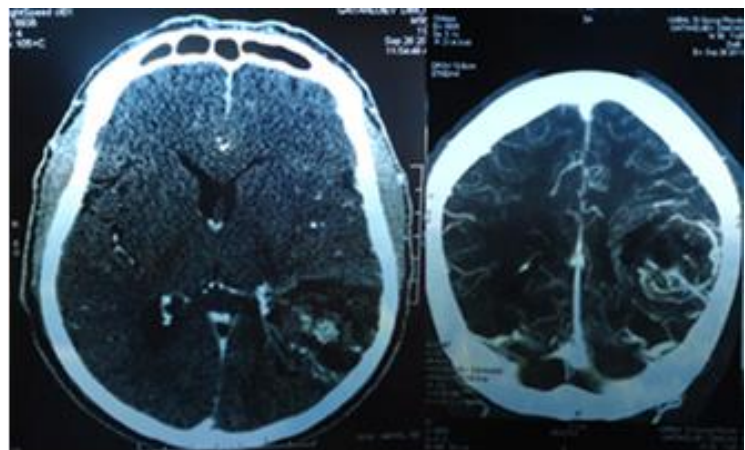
CT image (axial and transverse) of non-ruptured AVM
